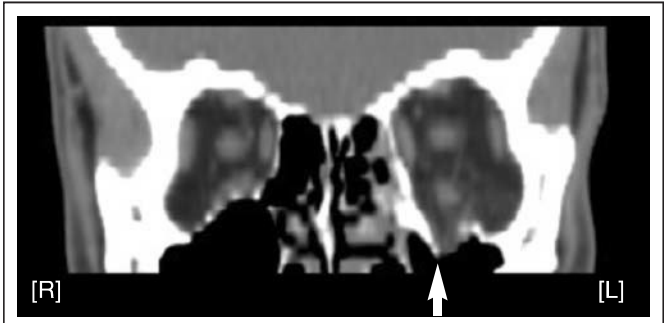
Orbital CT confirms fracture of the left orbital floor with herniation of contents into the left maxillary antrum
